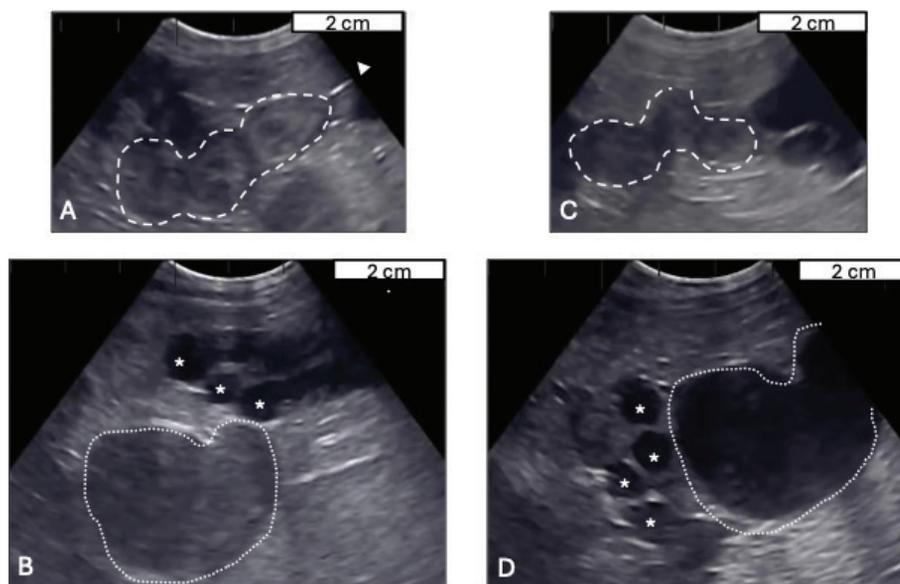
Transabdominal ultrasonographic images (obtained at 8 cm depth with 4.5-6.2 MHz probe) of the doe's uterus at first evaluation; A. small, nonpregnant, nonfluid-filled cross sections of uterine horns (white dashed line) and B. dilated uterine tube, hydrosalpinx (white asterisks), and distended fluid-filled uterus, hydrometra (white dotted line). Similar findings were obtained on reexamination after prostaglandin $F_{2\alpha}$ treatment; C. visible nonpregnant/nonfluid-filled sections of uterus (white dashed line) and D. persistent hydrosalpinx (white asterisks) and hydrometra (white dotted line). Images were taken at 8 cm of depth at 4.5-6.2MHz using an Ibex®eC6 multi-frequency probe
